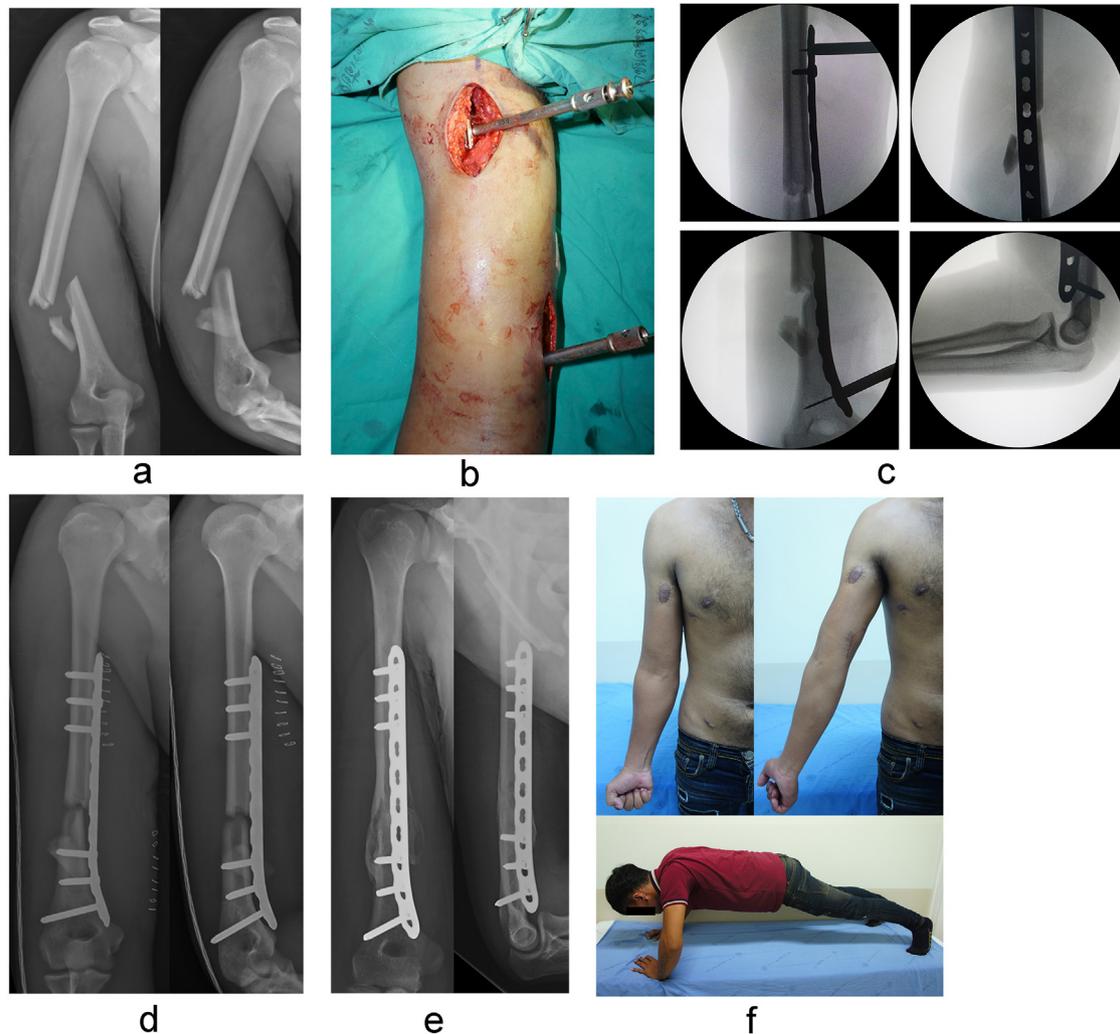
a. 20 year old male with fractured distal shaft of humerus, AO/OTA 12B-2. b. Distal and proximal incisions with the anteromedial MIPO approach. c. Intraoperative fluoroscopic images (AP and lateral views). d. Immediate postoperative x-rays. e. One year postoperative x-rays showing complete healing with callus bridging the fracture. f. Well-hidden medial scar at the elbow with full recovery of function.
